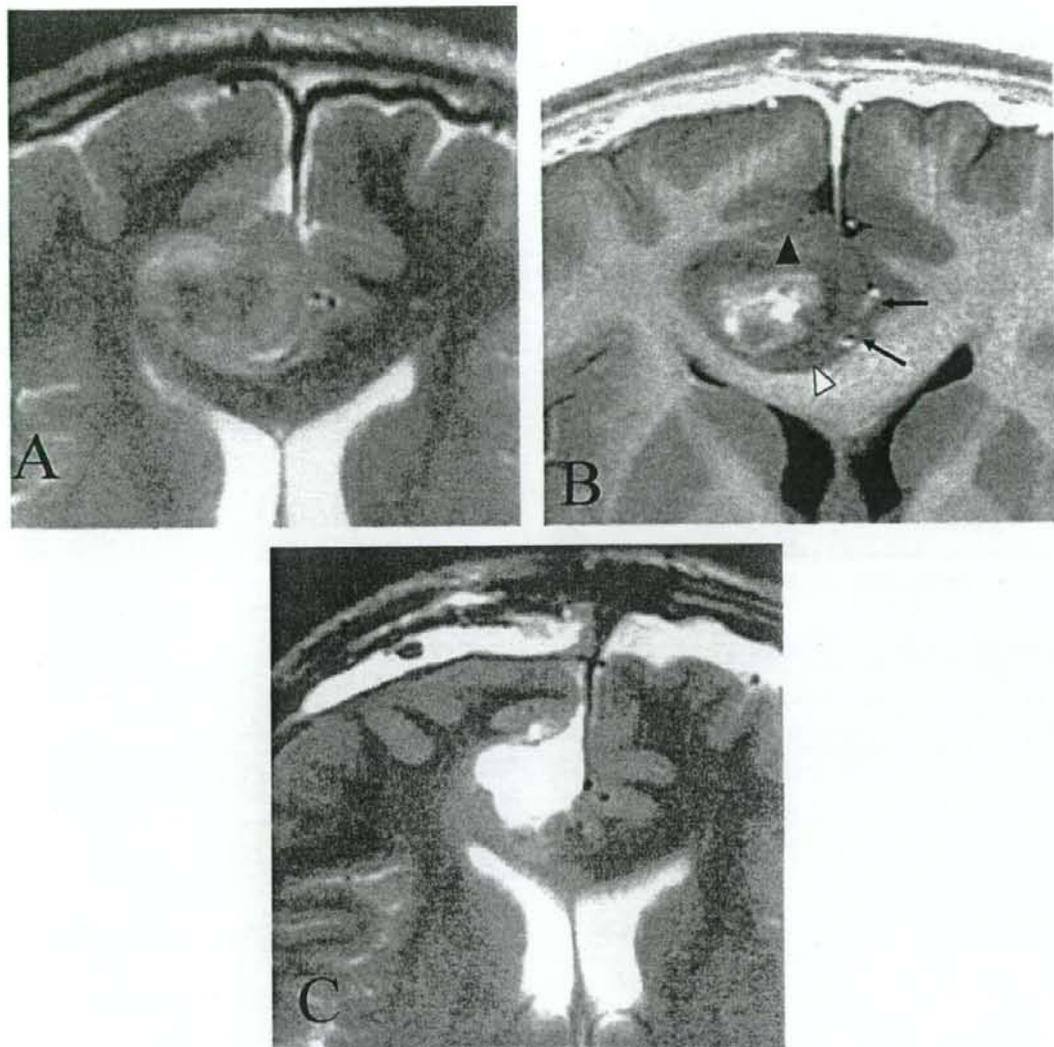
Images for Case 4. Axial T2WI using 1.5T MRI (A) and axial STIR image using 3.0T MRI (B). Black arrowhead: the cingulate sulcus, white arrowhead: corpus callosum sulcus, arrows: the pericallosal and callosomarginal arteries. Postoperative T2WI using 1.5T MRI (C) performed at a different hospital demonstrates satisfactory removal of the tumor bulk.
